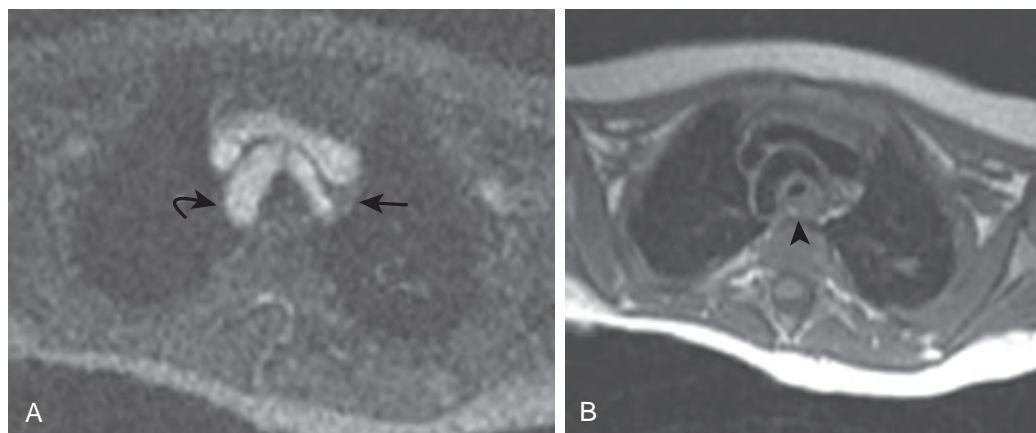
Double aortic arch: MR findings. A. White blood, steady-state free precession image demonstrates larger right (curved arrow) and smaller left (straight arrow) aortic arches. B. Corresponding black blood T1-weighted image shows the double aortic arches encircling the trachea and the collapsed esophagus (arrowhead).
